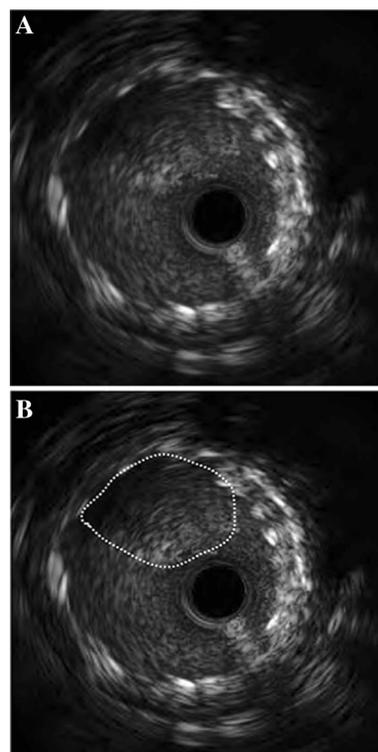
Representative intravascular ultrasound image of tissue protrusion. Intravascular ultrasound images (a, b) show intrusion of the tissue through the stent struts into the lumen as tissue protrusion (dotted line in b)
